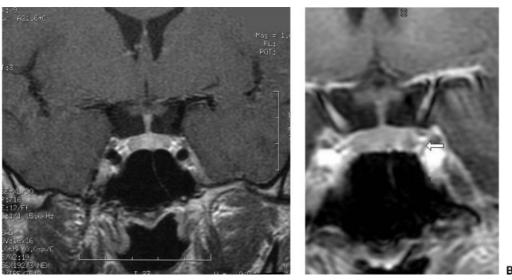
(Case 5) (A) T1-weighted coronal 1.5T MRI with contrast shows no clear tumor margins. The radiologist's interpretation stated "probable 5.5-mm right-sided pituitary adenoma." IPSS could only be obtained on the right side. (B) T1-weighted coronal 3T MRI shows a left-sided hypointensity relative to the surrounding enhancing gland (arrow). This finding is consistent with a pituitary microadenoma, which was confirmed during surgical exploration. IPSS, inferior petrosal sinus sampling.
